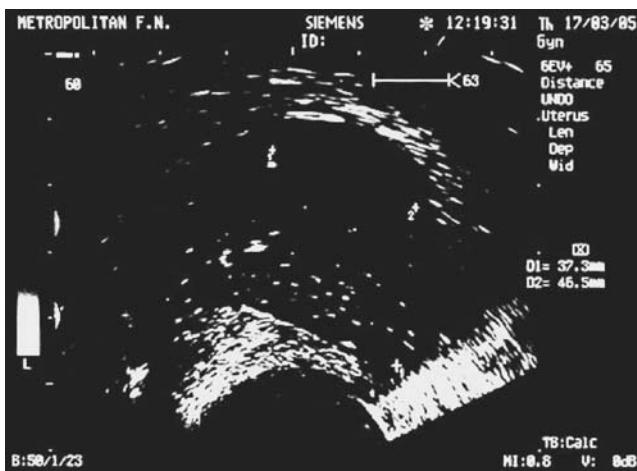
Ultrasound pictures of *Enterobius vermicularis* infection in uterus
